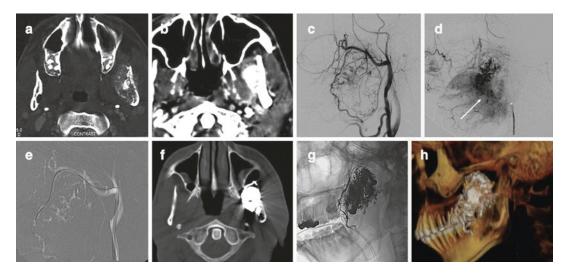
Young boy with firm swelling in the left check region. (a) CT scan shows an expansile lytic lesion in the rams of the left mandible with soft tissue adjacent to it. (b) Post-contrast CT images showing intense contrast enhancement. (c, d) Catheter angiography shows slow
